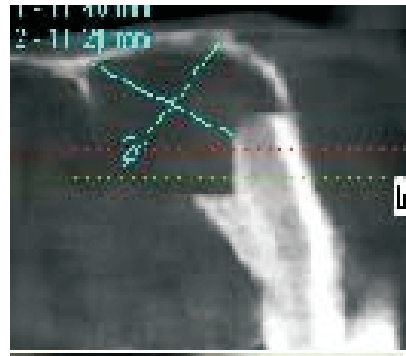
CBCT image of lateral incisor
